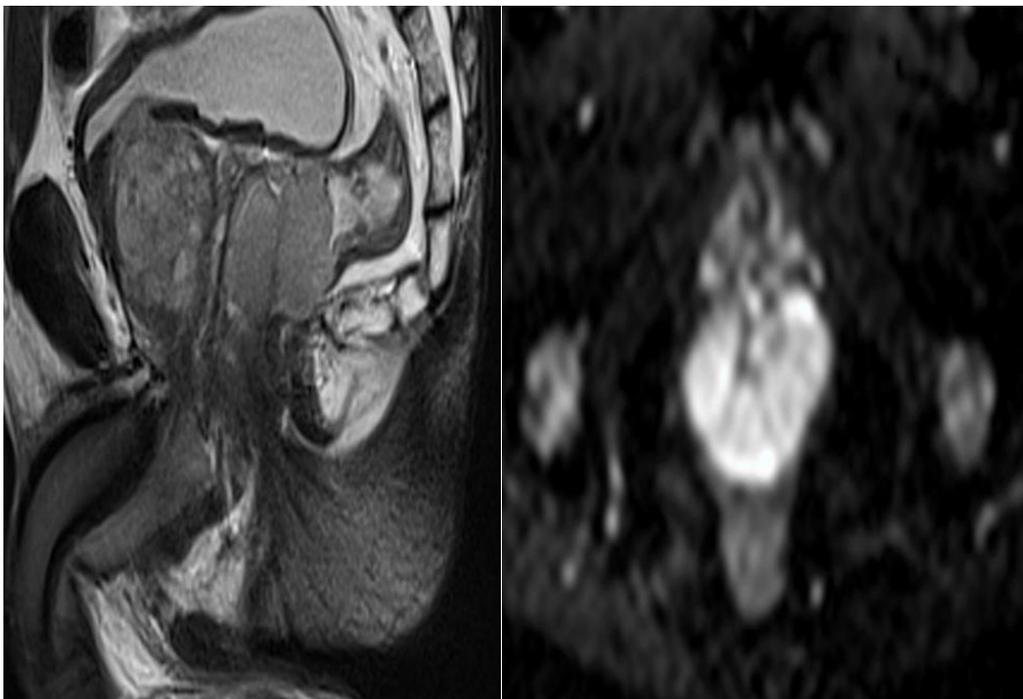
Pelvic MRI: evidence of a circumferential tumor thickening of the low rectum extended towards the anal canal measuring 28 mm thick, spread over 43 mm in height and whose lower pole comes into contact with the anal margin with Respect of the sphincter apparatus and neighborhood structures with voluminous pelvic adenopathy over the bladder measuring 34 * 36 mm and prostatic hypertrophy
